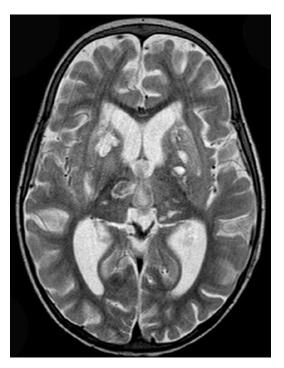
T2-weighted MRI scan of a child with tuberculous meningitis (TBM) showing multiple bilateral infarcts in the basal ganglia and thalami
